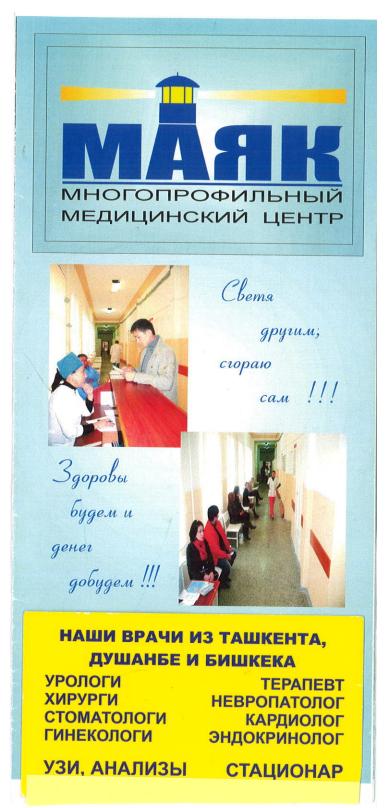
Part of a pamphlet advertising a commercial medical clinic "Maiak" in Moscow that is oriented toward serving Central Asians. The text translates as follows (from top to bottom, left to right): Maiak [light house] / multi-profile / health-care center / By shining for others, I burn up myself [i.e., by serving others, I consume myself]!!! / We will be healthy and make money!!! / Our doctors are from Tashkent, Dushanbe and Bishkek / Urologists / Surgeons / Dentists / Gynecologists / Ultrasound, analyses / General practitioner / Neurologist / Cardiologist / Endocrinologist / In-patient treatment
